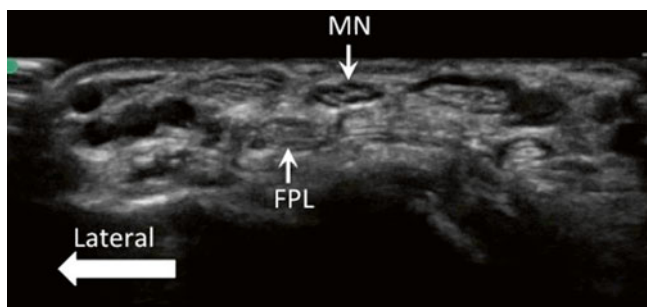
Sonogram of the median nerve (MN) at the proximal palmar crease. At this level, the median nerve is usually superficial and on the ulnar side of the flexor pollicis longus (FPL) (Reproduced with permission from Philip Peng Educational Series)
